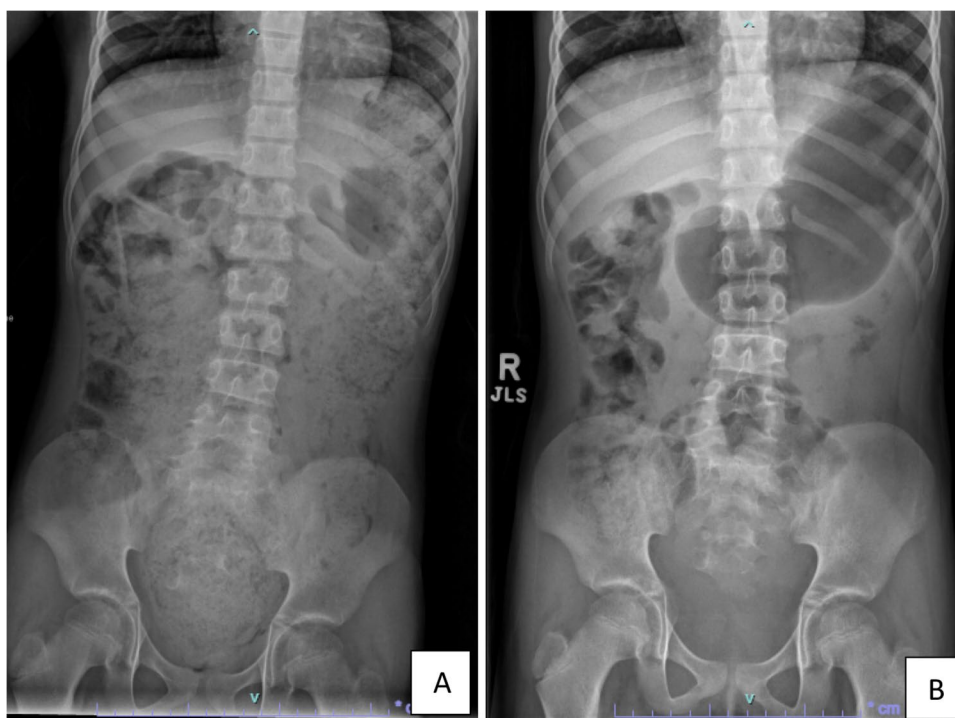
Patient with an anorectal malformation during bowel management with laxatives. Abdominal radiograph shows persistent stool in the rectum
